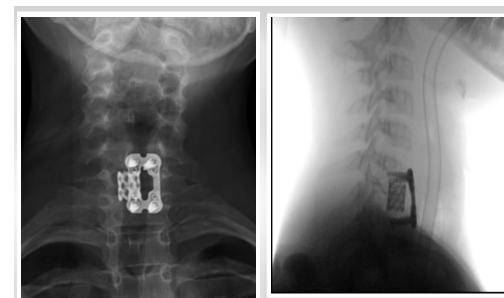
X-rays, anteroposterior view of the cervical spine after the first surgery. X-rays show seventh cervical corporectomy with placement of a titanium mesh cage, followed by anterior fixation of the sixth cervical and first thoracic vertebrae.
